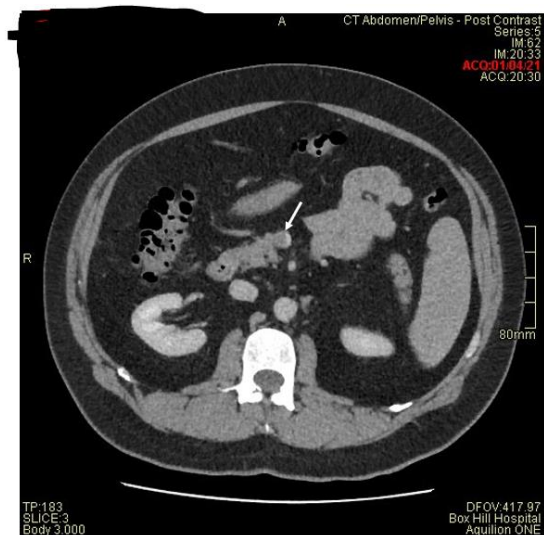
CT-venogram at presentation showing thrombus in superior mesenteric vein (white arrow shows contrast, axial plane)
